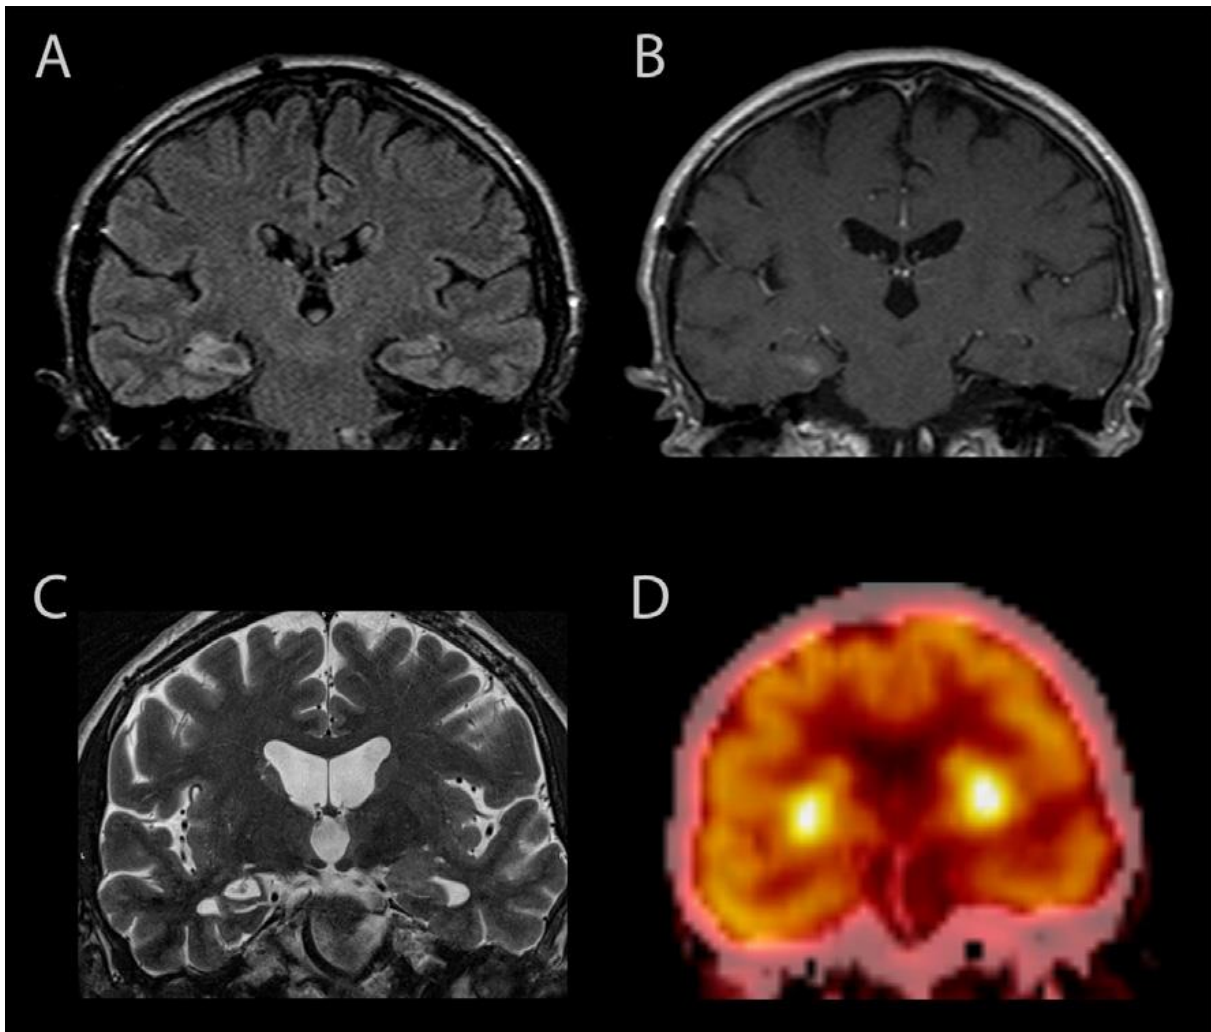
MRI and FDG-PET imaging in LGII encephalitis. (A–C) 60-year-old male patient with LGII encephalitis: FLAIR-hyperintense signal alterations in the hippocampus bilaterally (right > left; A), with contrast enhancement on the right side (B). The patient presented with frequent faciobrachial dystonic seizures (FBDS), followed by confusion, agitation, and severe memory impairment. Following immunotherapy with IV steroids, plasma exchange and IV immunoglobulins FBDS ceased while memory impairment persisted. Follow-up MRI 17 months later showed bilateral (right > left) atrophy of the hippocampus as well as moderate global atrophy (C). (D) FDG-PET showing bilateral hypermetabolism in the basal ganglia in a 92-year-old patient that presented with up to 100 FBDS/day but without cognitive deficits. FBDS stopped after two courses of IV immunoglobulin therapy. MRI was unremarkable except mild global atrophy and microangiopathic leukoencephalopathy and especially showed no abnormalities of basal ganglia or medial temporal lobes.¹¹⁸
